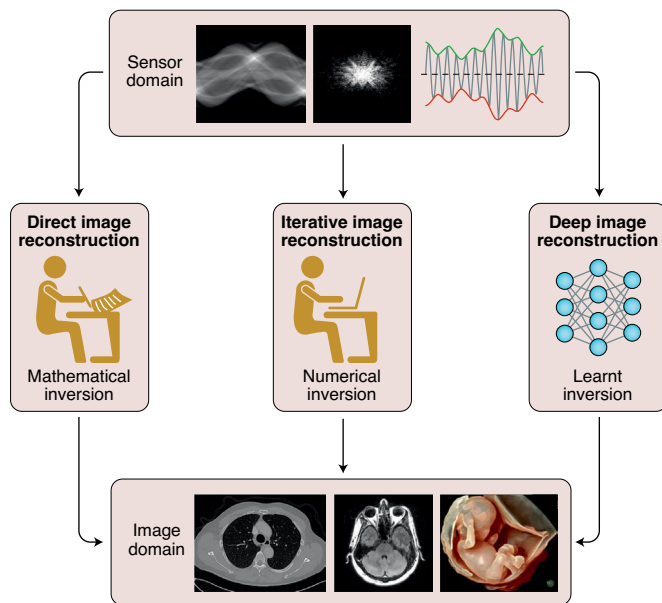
Three types of tomographic reconstruction methods. In direct or analytic reconstruction, a mathematical inverse of the forward transform is used to compute images from sensor data. In iterative reconstruction, the current image estimate is iteratively updated such that its forward transform gradually approaches the sensor data. In deep tomographic reconstruction, the inversion does not need to rely on any explicit transform model but is learnt from representative big data. Credit: Molly Freimuth (CT image); Christopher Hardy (MR image); Dawn Fessett (ultrasound image).
